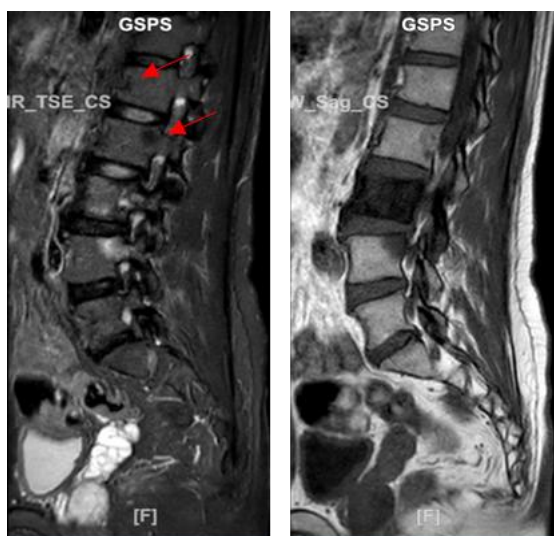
Thoracolumbar MRI showed sclerotic lesions in L2-L3
